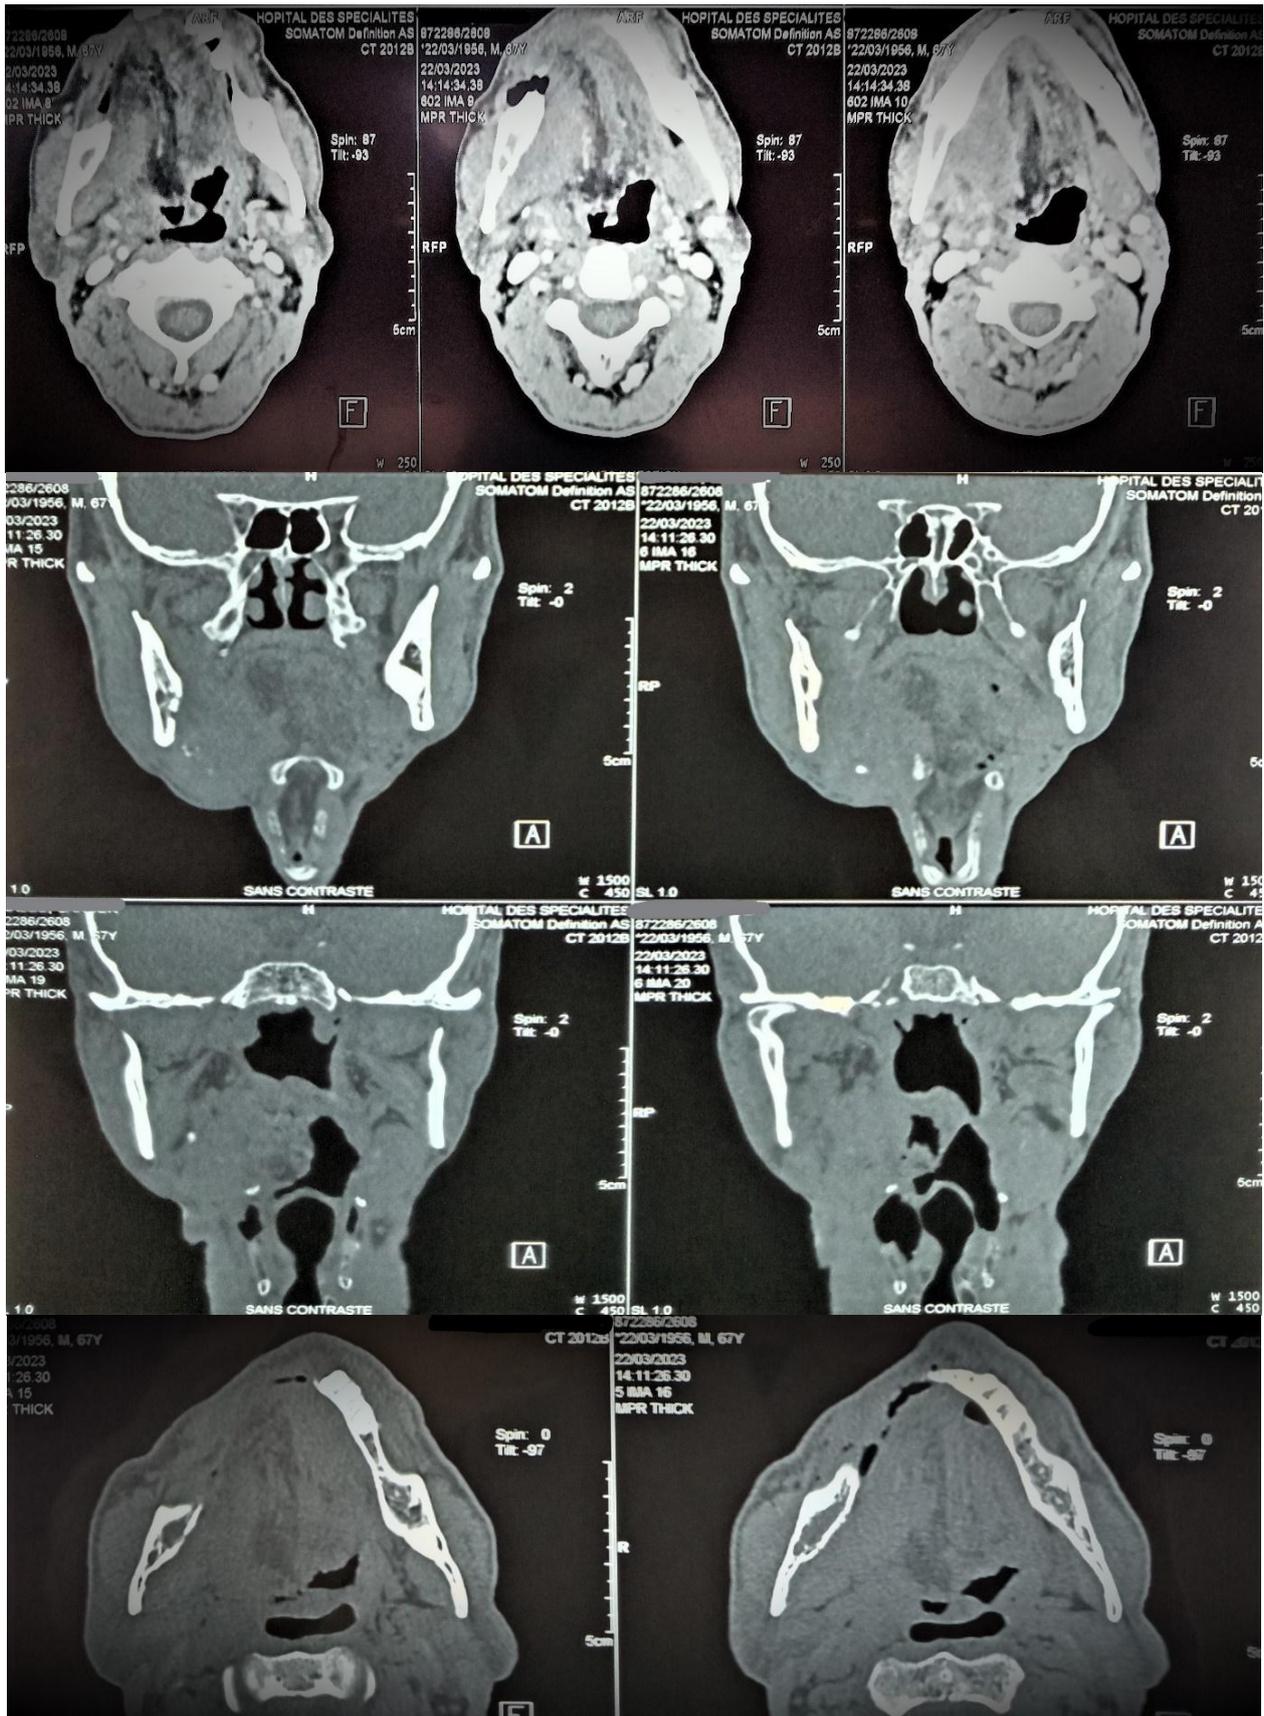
CT images of the patient showing the locally advanced lesion process in the right mandibular region.
